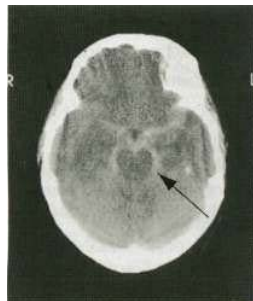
CT: Subarachnoid haemorrhage showing blood around the brain stem (arrow).
